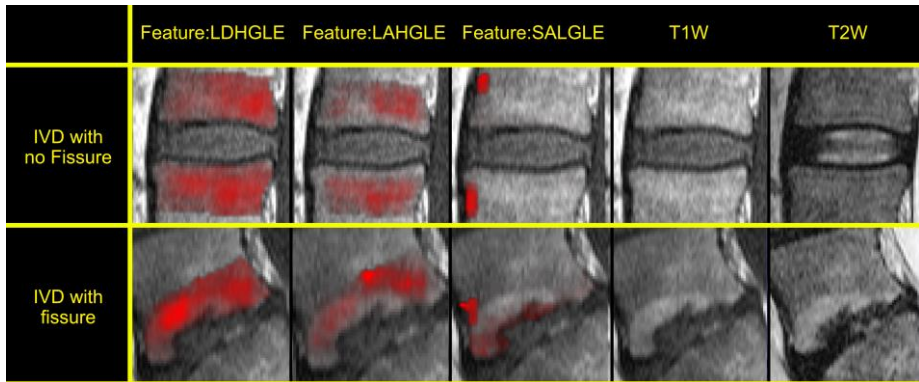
Examples of feature maps overlaid onto T1W images of the vertebra. In the examples, the logistic regression correctly classified the adjacent IVD. T1-weighted (T1W) and T2-weighted (T2W) images with no overlay are added for reference.
